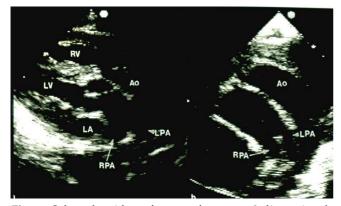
Selected video frames from a 2-dimensional echocardiographic views of an infant with transposition of the great arteries. In a, note the great vessel coming off of the left ventricle (LV) courses posteriorly and bifurcates into left (LPA) and right (RPA) pulmonary arteries. In b. posterior vessel is similarly seen to bifurcate. The anterior vessel is aorta (Ao). LA, left atrium; RV, right ventricle.
